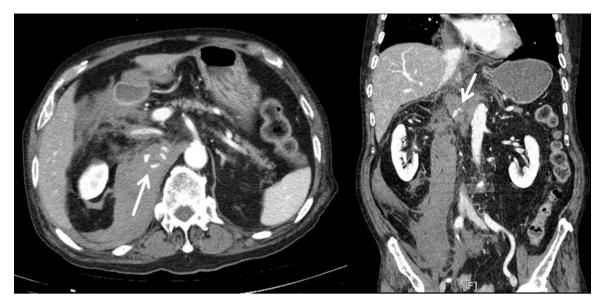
Initial contrast-enhanced abdominal CT scan, showing contrast medium extravasation medial to the right kidney.
